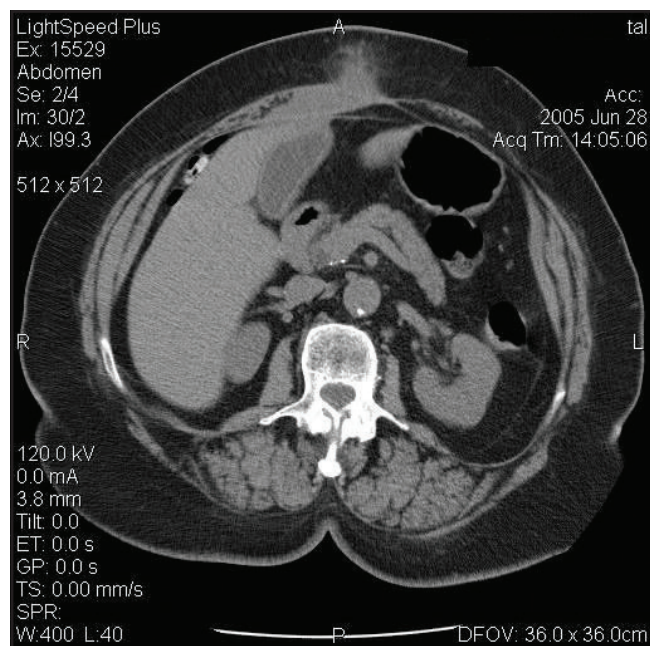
CT scan showing cholecystocutaneous fistula
